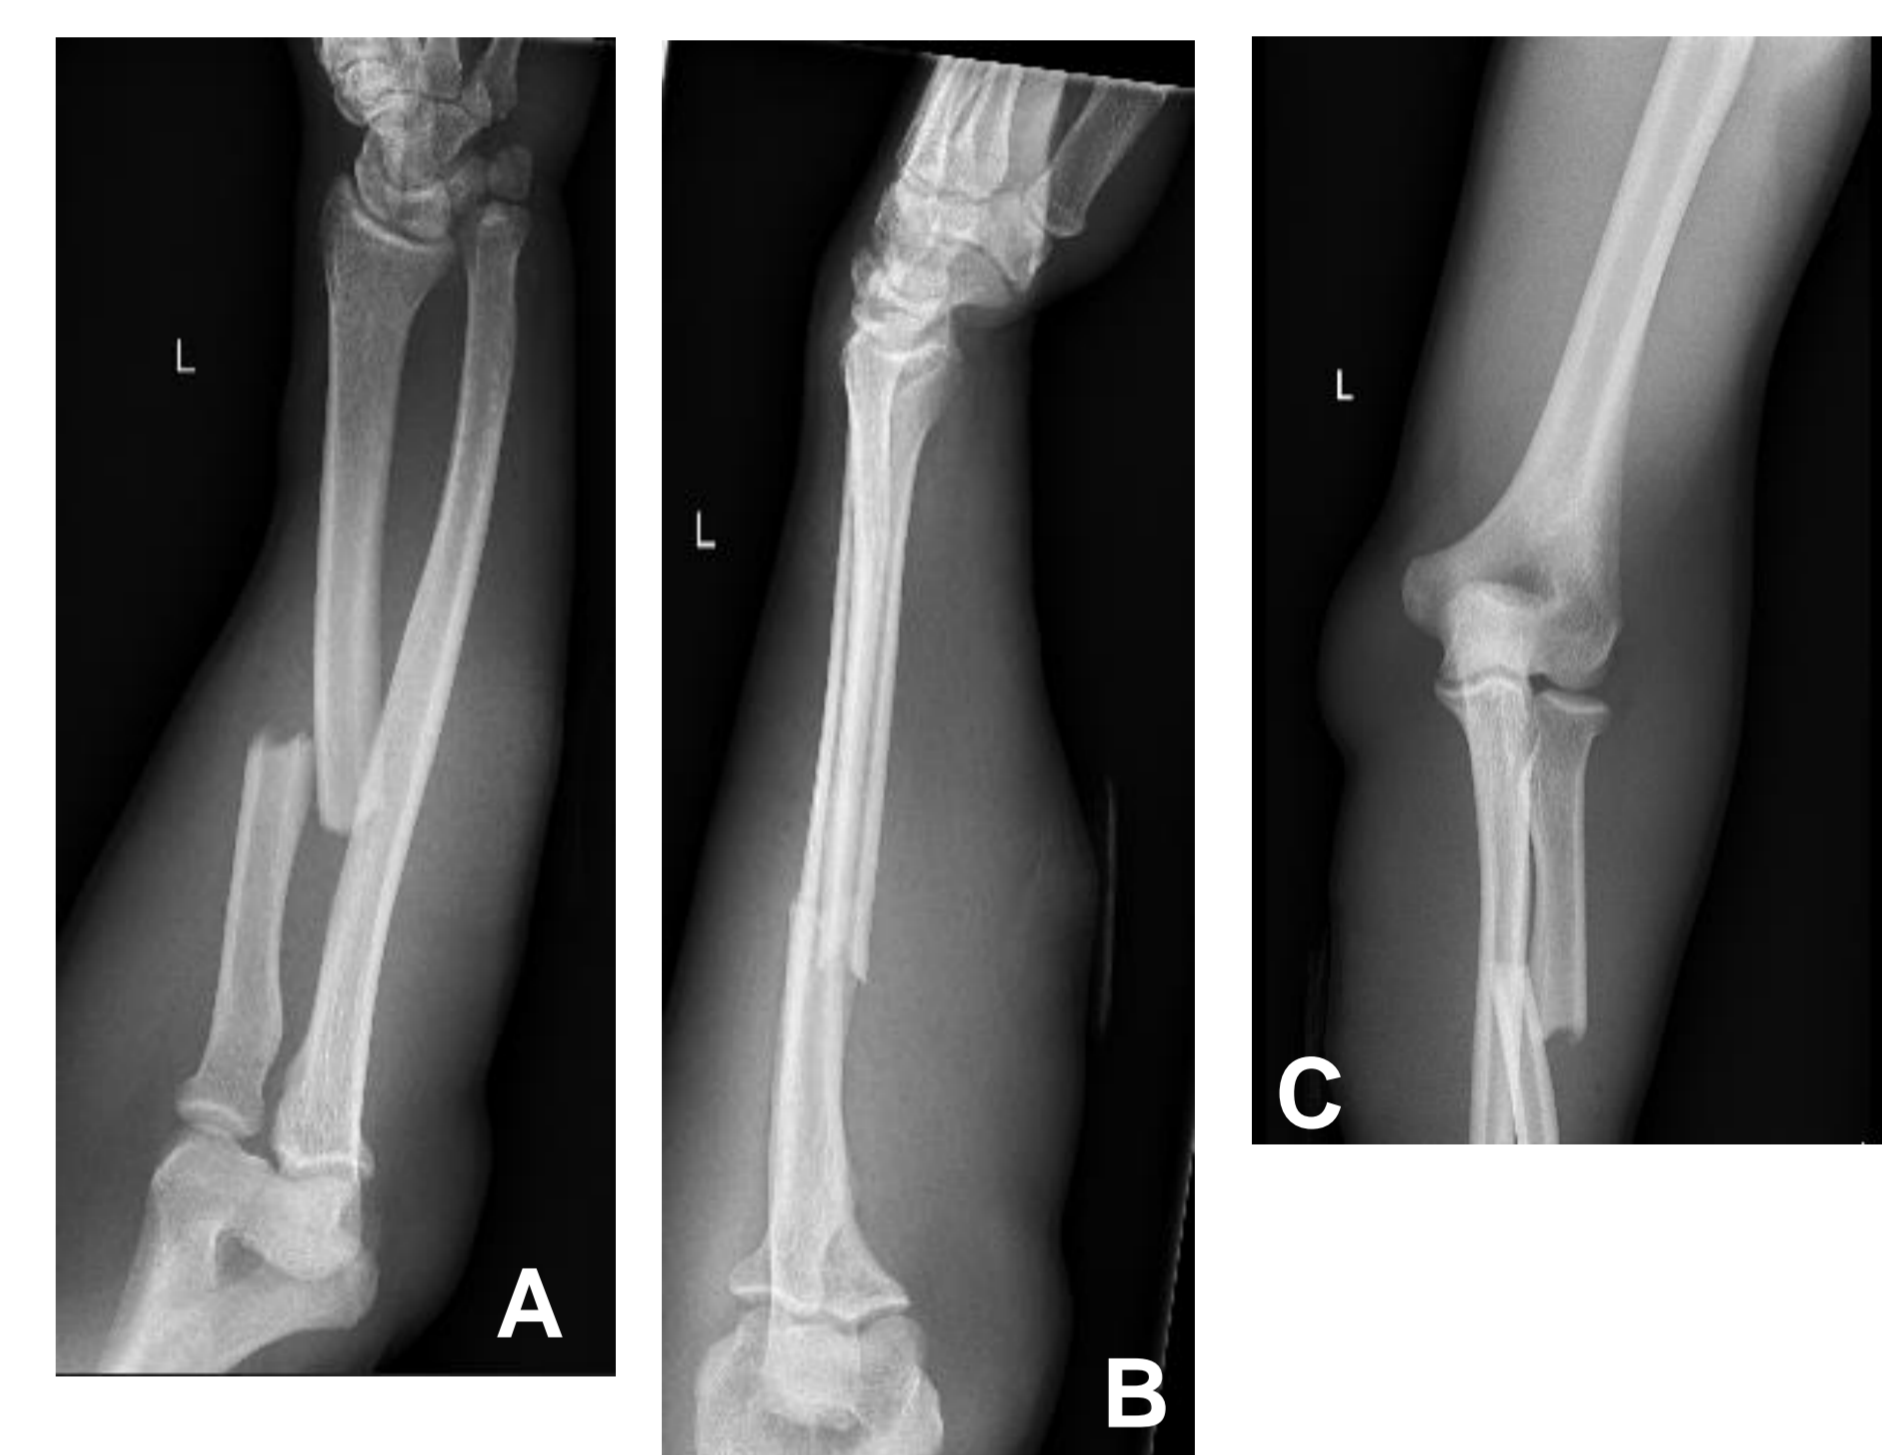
Preoperative Radiographs:
